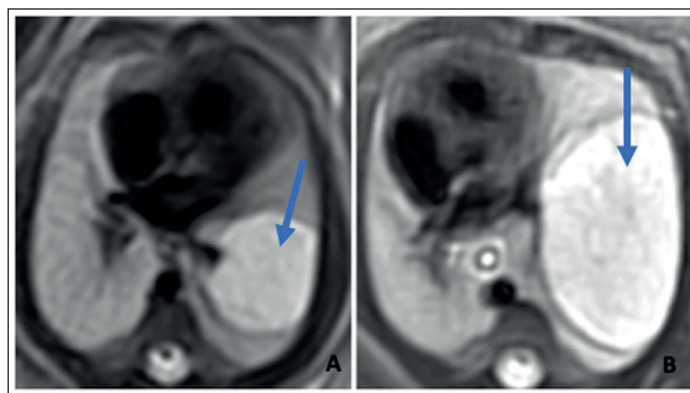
A and B Correspond to different cross-sections of magnetic resonance imaging (MRI) performed during the gestation period. A. was performed at 32 weeks gestational age (GA), while B. was performed at 37 weeks of GA. In both studies, a lung mass (arrow) can be visualized, at that time described as congenital pulmonary malformation (CPM). An increase in lesion size can be observed between the two studies, with a few weeks of gestation apart.
